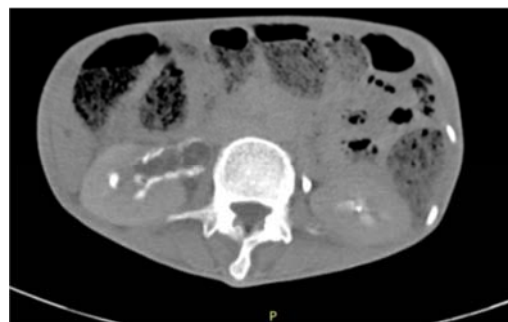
CT abdomen imaging shows right ureteric calculi causing hydronephrosis. Enhancement of renal pelvis and ureteric wall suggestive of pyelitis and urethritis.
